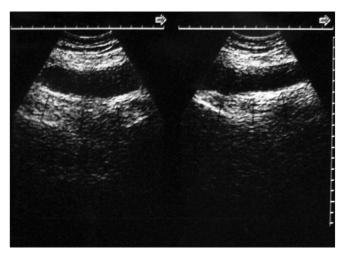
Ultrasonography reveals a well-defined hypoechoic homogeneous mass 10 × 8 cm in diameter
